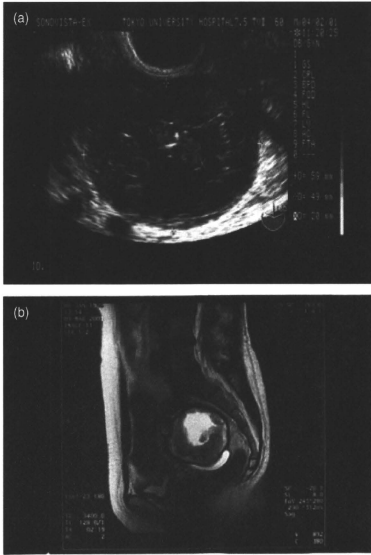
(a) Transvaginal ultrasonography revealed a right adnexal cystic mass with irregular thick capsule containing a fetus-like image. (b) Magnetic resonance imaging, T2-weighted. α FP, α -fetoprotein.
